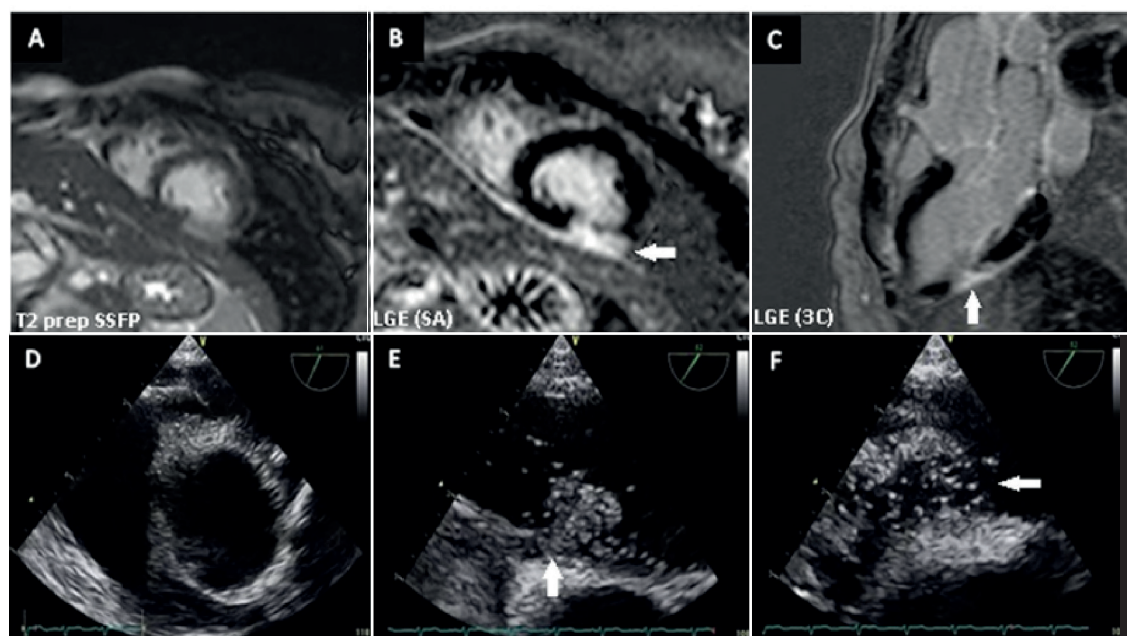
(A-C) A small area of transmural enhancement on the inferolateral wall, in the transition between a middle and an apical third, an area with evidence of hypersignal in the T2-weighted sequences (in this case, a T2 prep SSFP). (D-F) TEE with stretched patent foramen ovale.
